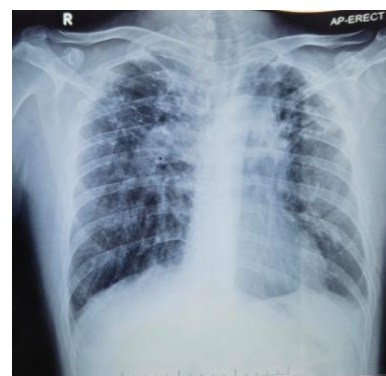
Chest X-ray showed fibrosis in both lungs
